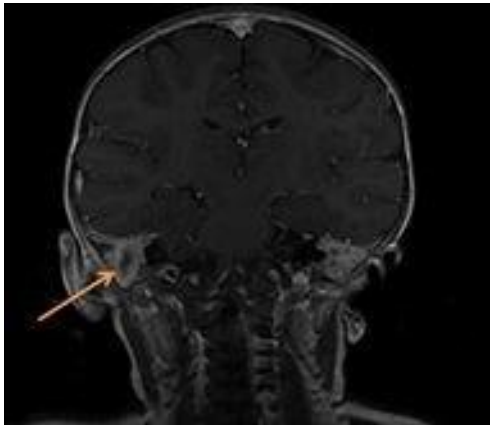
Post-contrast T1 coronal MRI (series 4, image 21) with 0.6 x 0.4 x 1.0 cm rim-enhancing, centrally non-enhancing fluid collection in right mastoid bone (arrow) and bilateral enhancement of the mastoids consistent with mastoiditis.
